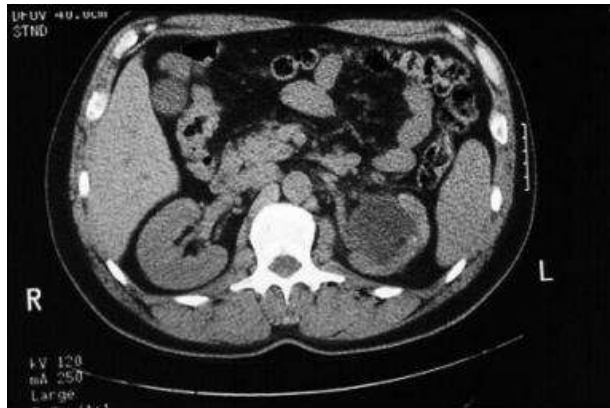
CT scan without contrast demonstrating severe left-sided hydronephrosis secondary to ureteropelvic junction obstruction.
